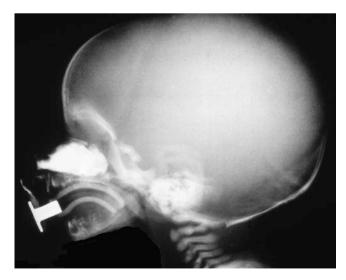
X-ray of choanal atresia showing dye in the obstructed choanal region
